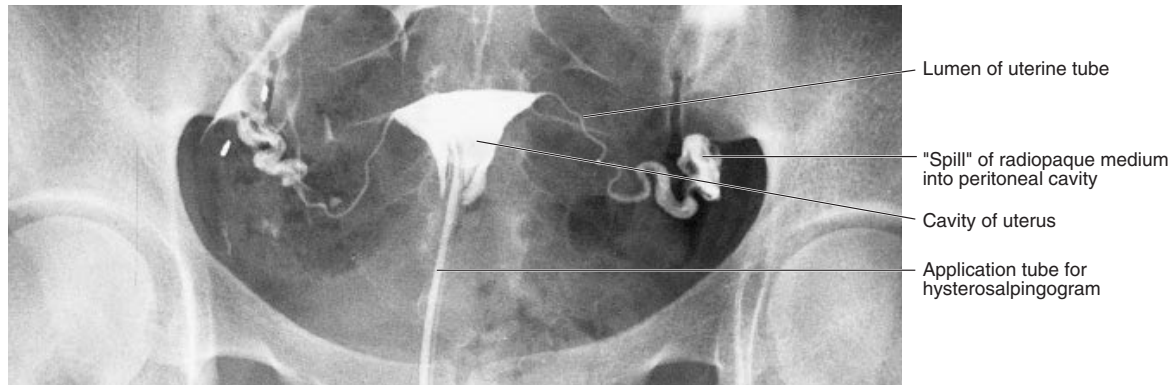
A contrast radiograph of the uterine cavity and lumina of the uterine tubes (hysterosalpingogram).
